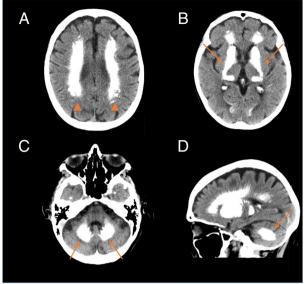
Widespread brain calcifications. (A–D) Axial brain computed tomography (A–C) and paramidsagittal sections (D) with the patient at age 72 years display widespread and confluent calcifications mainly in the gray matter (arrows). The affected areas are all the basal ganglia, thalamus, dentate nuclei, and vermis. The white matter is affected to a lesser degree (arrowheads). Total calcification score was 62 (range = 0–80) and remained unchanged 2 years later. (E) Oromandibular dystonia is evident in the still image. The patient provided consent to use a photograph of her face. [Color figure can be viewed at www.annalsofneurology.org]
